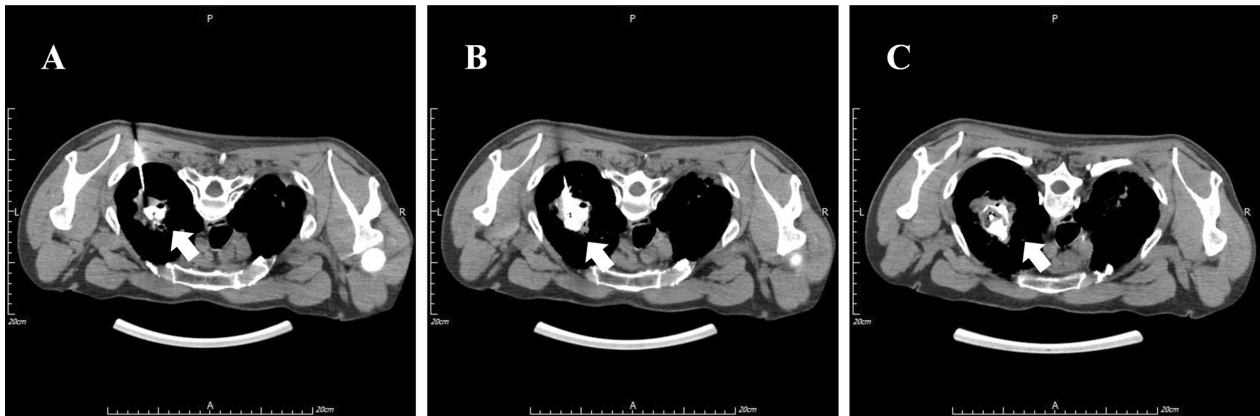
(A–C) Demonstration of CT-guided catheter placement within aspergilloma cavities and the mixed application of Iohexol injection prompted that the drug was injected into the cavity (white arrow).
